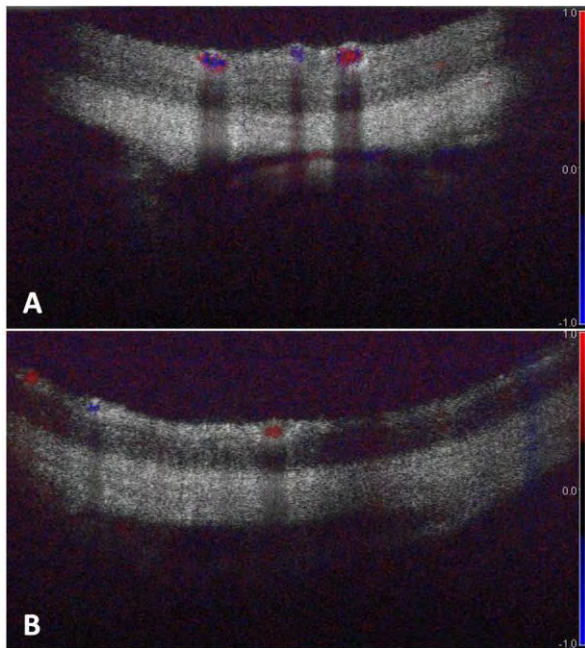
Retina vascularization with Doppler. A: Control retina; B: Transplanted retina.
